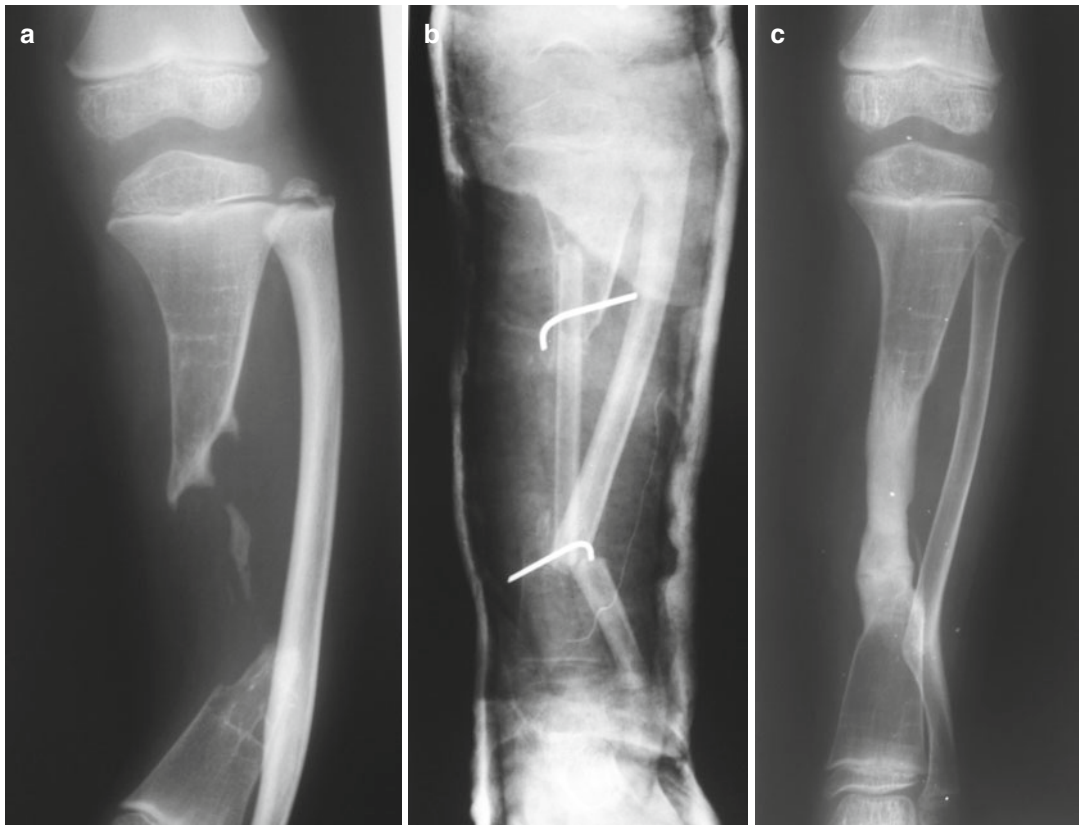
(a) X-ray of a boy who presented after a 2-year history of illness, leg pain and previously discharging sinuses. (b) Contralateral free fibula graft with ipsilateral fibula osteotomy and augmentation has been performed. (c) X-ray after healing
